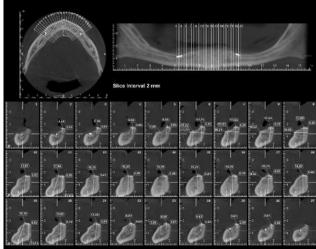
Preoperative CBCT of the mandible shows severe vertical bone resorption of the posterior alveolar ridges but adequate bone height and width of the symphysis.
